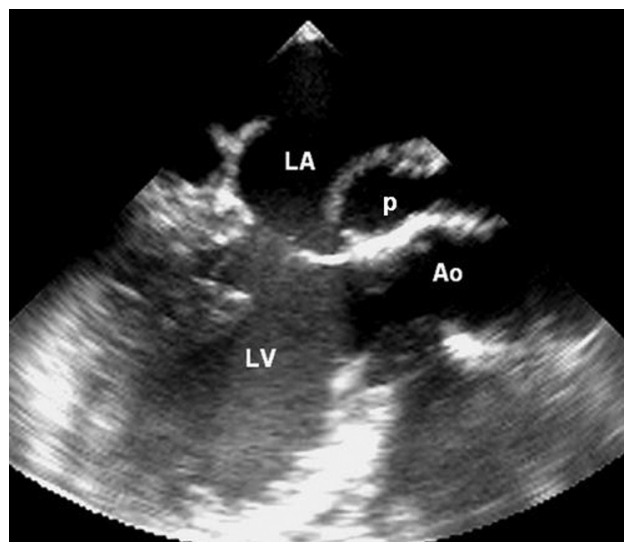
Transesophageal echocardiogram shows a pseudoaneurysm in a lateral view of the ascending aorta. LV indicates left ventricle; LA, left atrium; Ao, ascending aorta; p, pseudoaneurysm.
